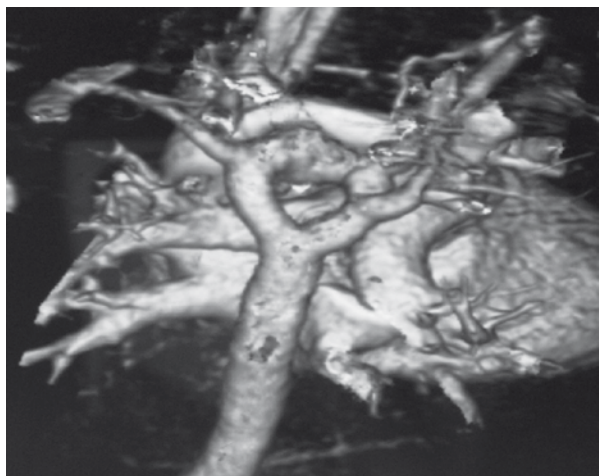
CT: a double aortic arch (the size of both arches 1:1)
